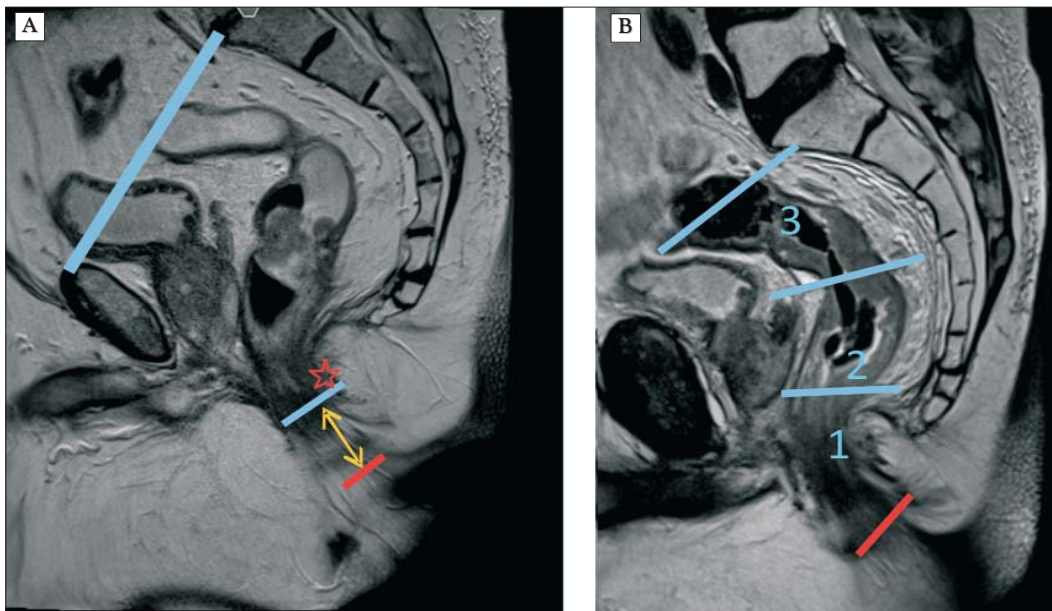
Sagittal T2 MRI of the rectum (A) The rectum is the final straight portion of the large intestine (between the blue lines). It begins at the rectosigmoid junction (end of the sigmoid colon), at the level of the sacral promontory. It ends at the level of the puborectalis sling (star) and it is followed by the anal canal (arrow). (B) The anal verge (red line) marks the furthest point of the anal canal. It is easy to identify in the physical examination and it is a surgical reference point. Also, the distance to the inferior tumour limit must be included. The distance to the anal verge divides rectal cancers in 1 - low rectal cancers (< 5 cm), 2 - mid rectal cancers (5-10 cm) and 3 - high rectal cancers (10-15 cm).
